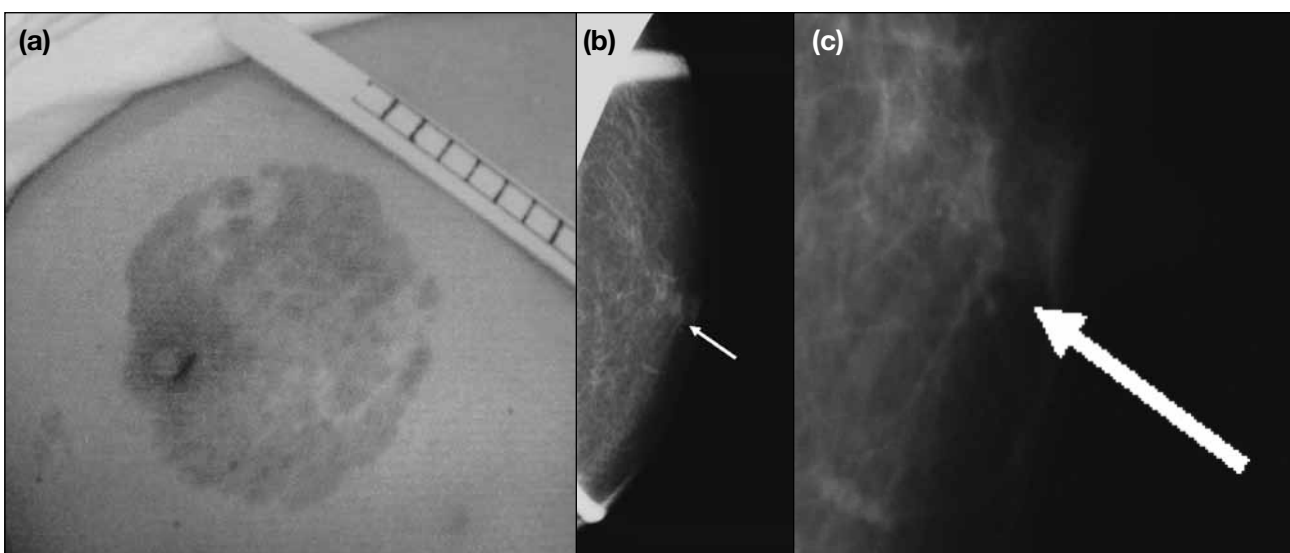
Paget's disease of male breast: (a) Clinical photo of a patient presenting with eczema at the areola and nipple of the right breast; skin biopsy confirmed it to be Paget's disease. (b) Cone magnification mammogram and (c) its close-up image revealing clustered pleomorphic calcifications (arrows) in retroareolar region. Ultrasound examination was unremarkable. Subsequent stereotactic-guided biopsy revealed atypical cells. The patient refused excision of the lesion and till now continues to receive conservative treatment.
